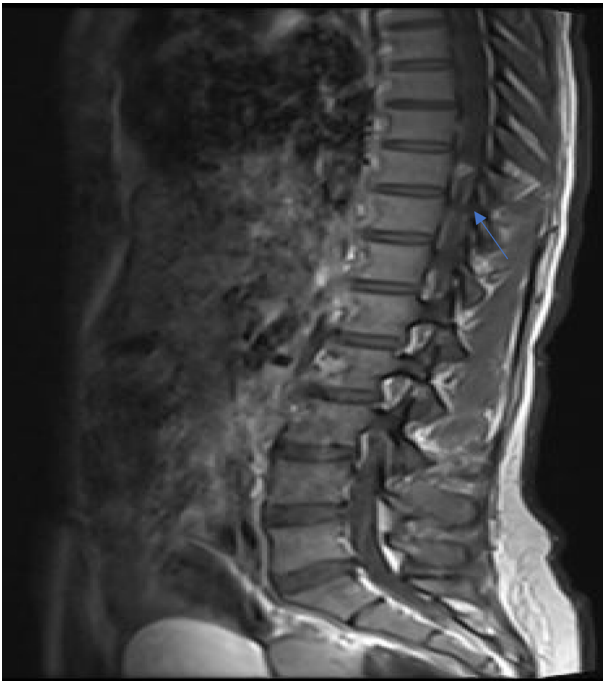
Sagittal T1 C+ (Gd) MRI of the toraco-lumbar spine shows the presence of a homogeneous and well-circumscribed extra-axial mass with homogeneous enhancement and broad dural base at T10 level.
